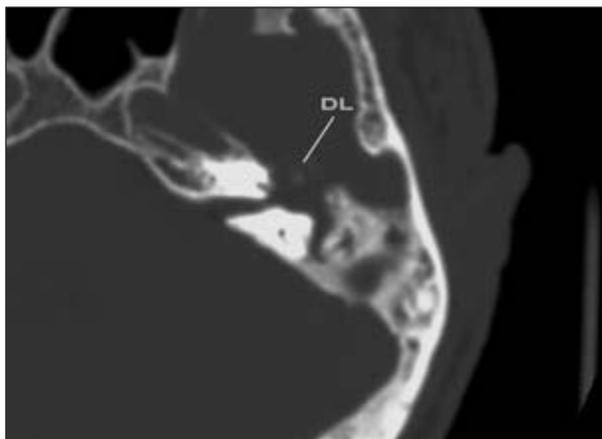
CT of temporal bone in a patient with tuberculous otitis
